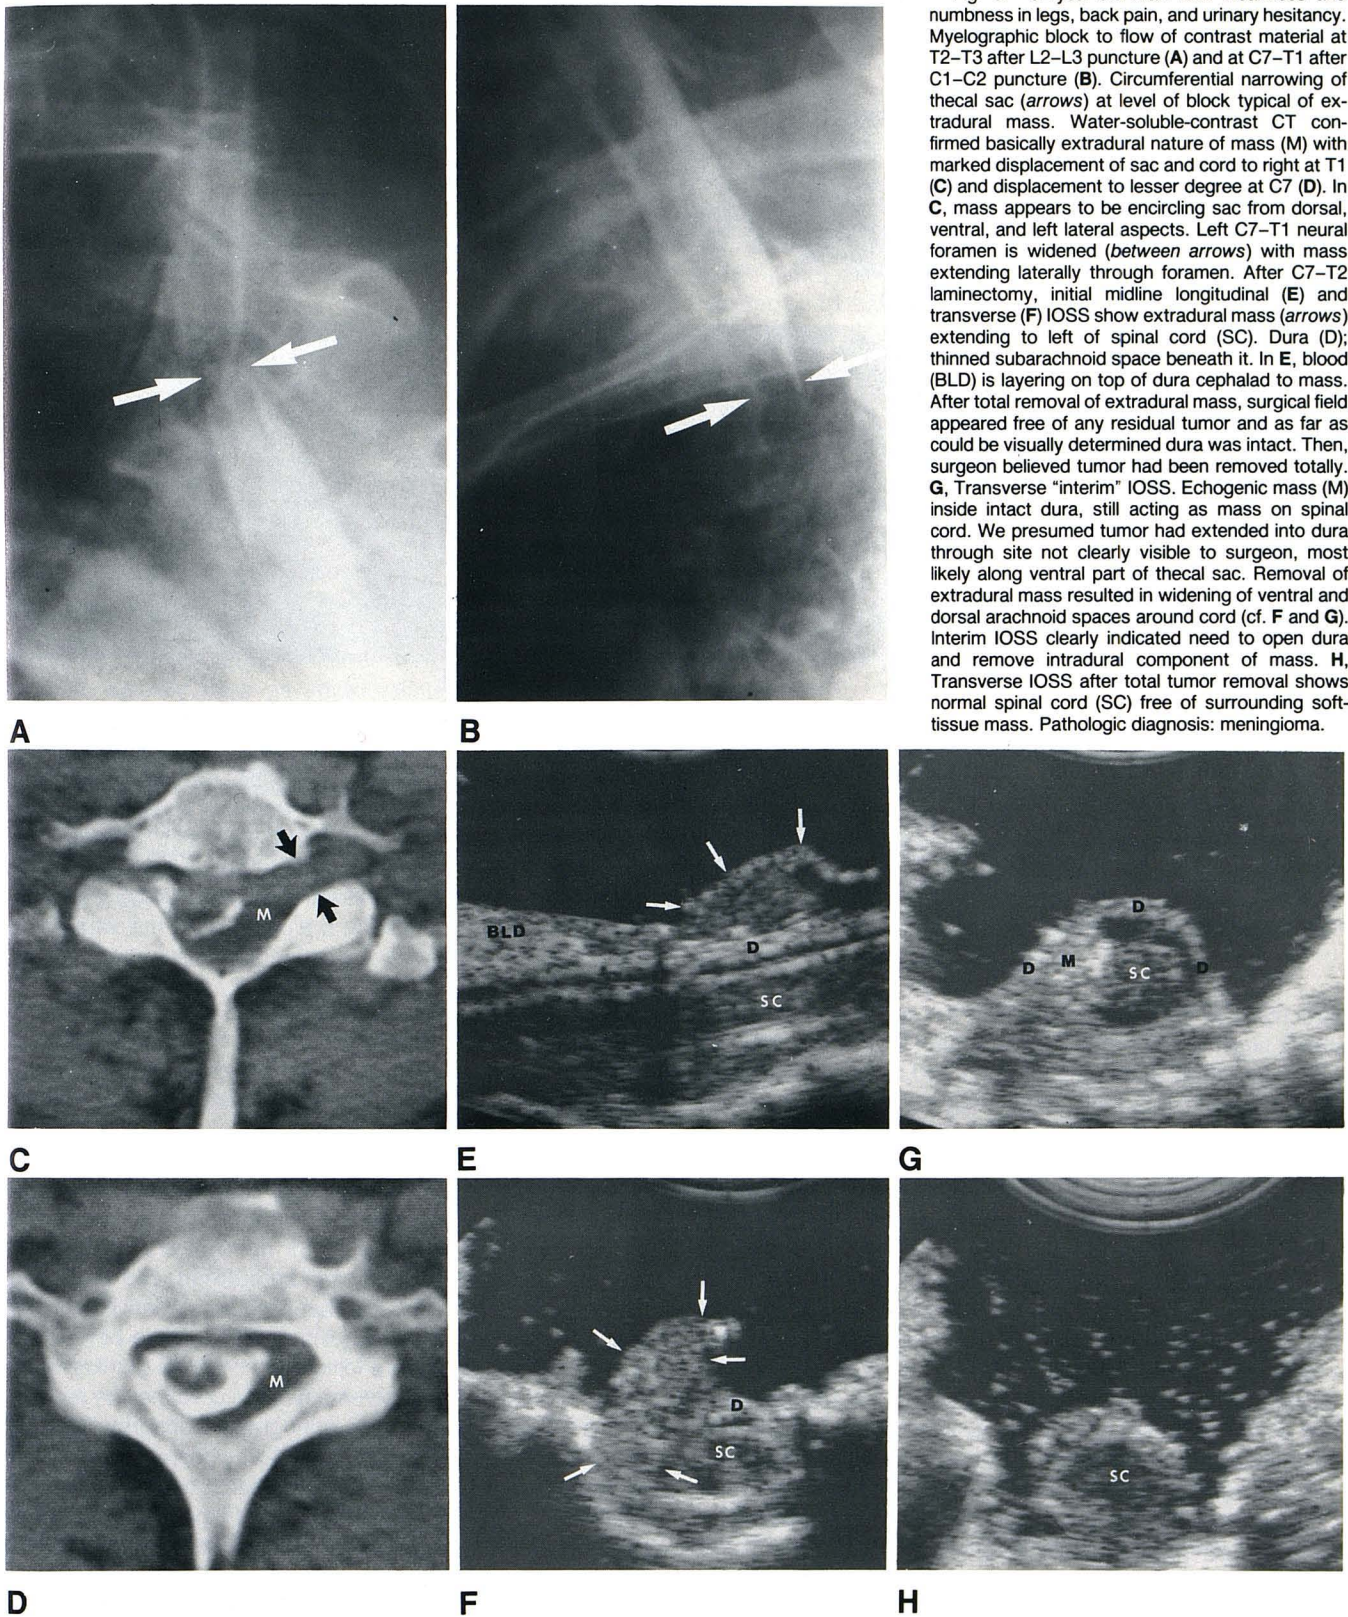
52-year-old man with weakness and numbness in legs, back pain, and urinary hesitancy. Myelographic block to flow of contrast material at T2-T3 after L2-L3 puncture (A) and at C7-T1 after C1-C2 puncture (B). Circumferential narrowing of thecal sac (arrows) at level of block typical of extradural mass. Water-soluble-contrast CT confirmed basically extradural nature of mass (M) with marked displacement of sac and cord to right at T1 (C) and displacement to lesser degree at C7 (D). In C, mass appears to be encircling sac from dorsal, ventral, and left lateral aspects. Left C7-T1 neural foramen is widened (between arrows) with mass extending laterally through foramen. After C7-T2 laminectomy, initial midline longitudinal (E) and transverse (F) IOSS show extradural mass (arrows) extending to left of spinal cord (SC). Dura (D); thinned subarachnoid space beneath it. In E, blood (BLD) is layering on top of dura cephalad to mass. After total removal of extradural mass, surgical field appeared free of any residual tumor and as far as could be visually determined dura was intact. Then, surgeon believed tumor had been removed totally. G, Transverse "interim" IOSS. Echogenic mass (M) inside intact dura, still acting as mass on spinal cord. We presumed tumor had extended into dura through site not clearly visible to surgeon, most likely along ventral part of thecal sac. Removal of extradural mass resulted in widening of ventral and dorsal arachnoid spaces around cord (cf. F and G). Interim IOSS clearly indicated need to open dura and remove intradural component of mass. H, Transverse IOSS after total tumor removal shows normal spinal cord (SC) free of surrounding soft-tissue mass. Pathologic diagnosis: meningioma.
